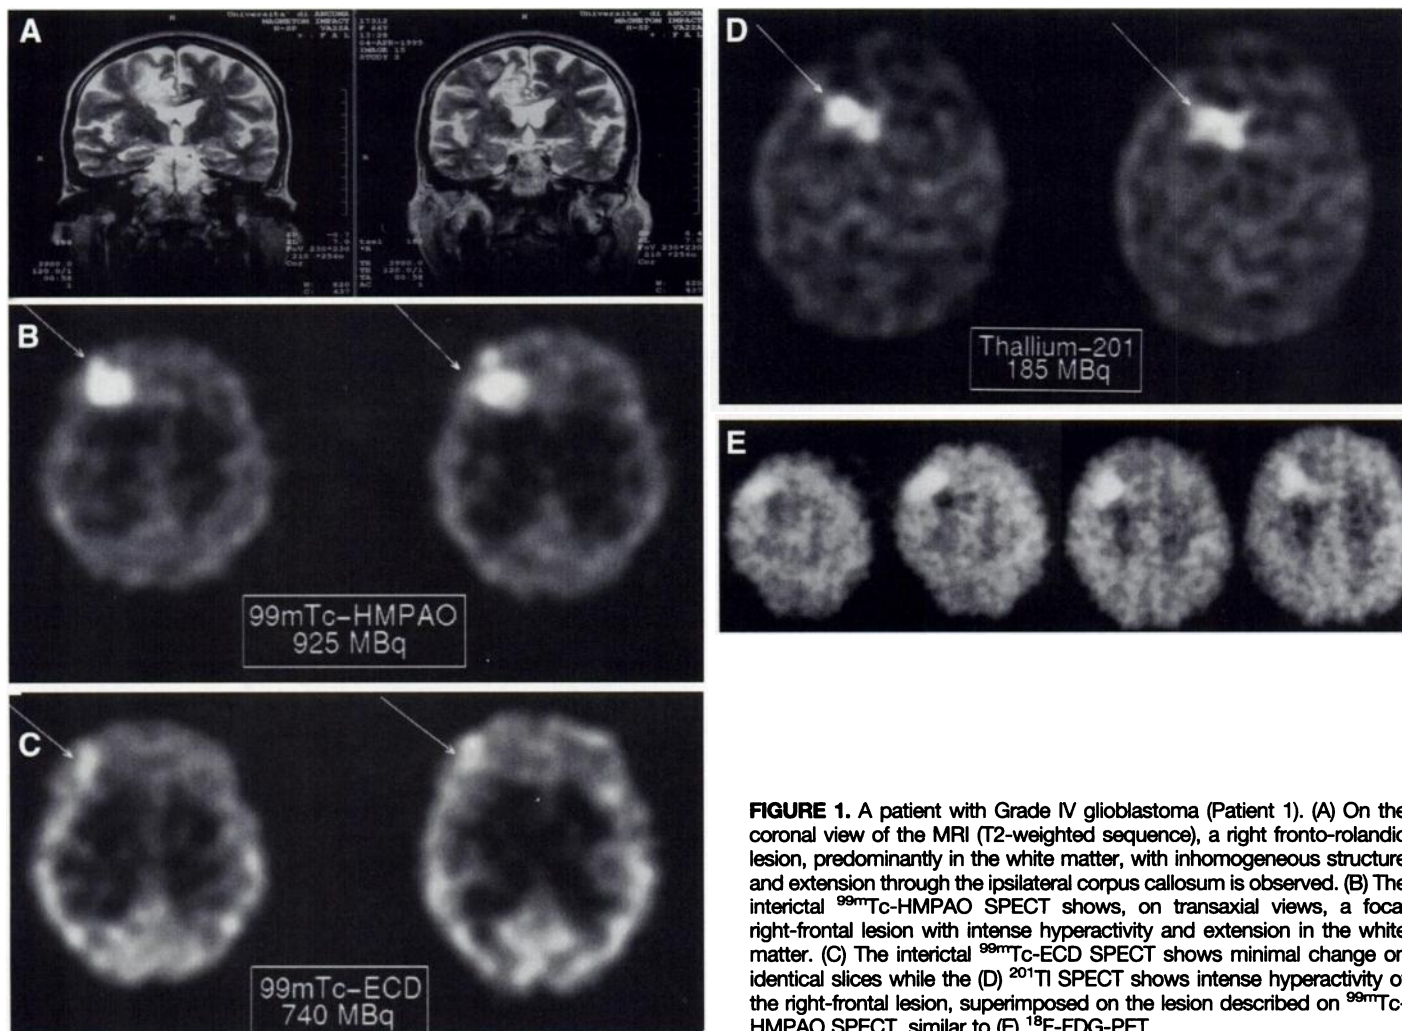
A patient with Grade IV glioblastoma (Patient 1). (A) On the coronal view of the MRI (T2-weighted sequence), a right fronto-rolandic lesion, predominantly in the white matter, with inhomogeneous structure and extension through the ipsilateral corpus callosum is observed. (B) The interictal ^{99m}Tc -HMPAO SPECT shows, on transaxial views, a focal right-frontal lesion with intense hyperactivity and extension in the white matter. (C) The interictal ^{99m}Tc -ECD SPECT shows minimal change on identical slices while the (D) ^{201}Tl SPECT shows intense hyperactivity of the right-frontal lesion, superimposed on the lesion described on ^{99m}Tc -HMPAO SPECT, similar to (E) ^{18}F -FDG-PET.
